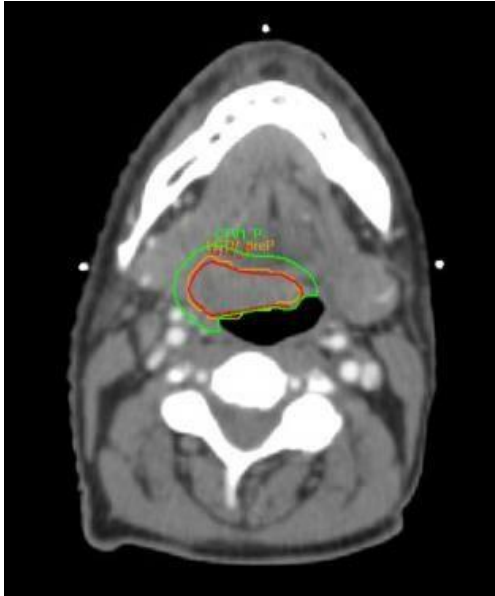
Cross sectional imaging of the phase 1 planning CT. bGTV\_preP contoured in orange, final GTV\_P in red and CTV1\_P in green.
